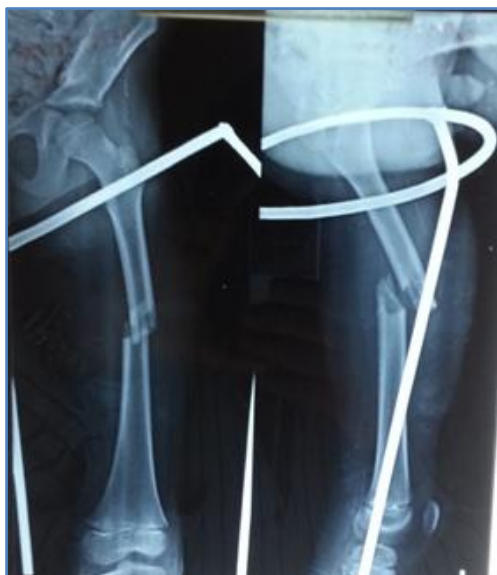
X-ray images of fracture shaft femur 9 year old boy: pre op
